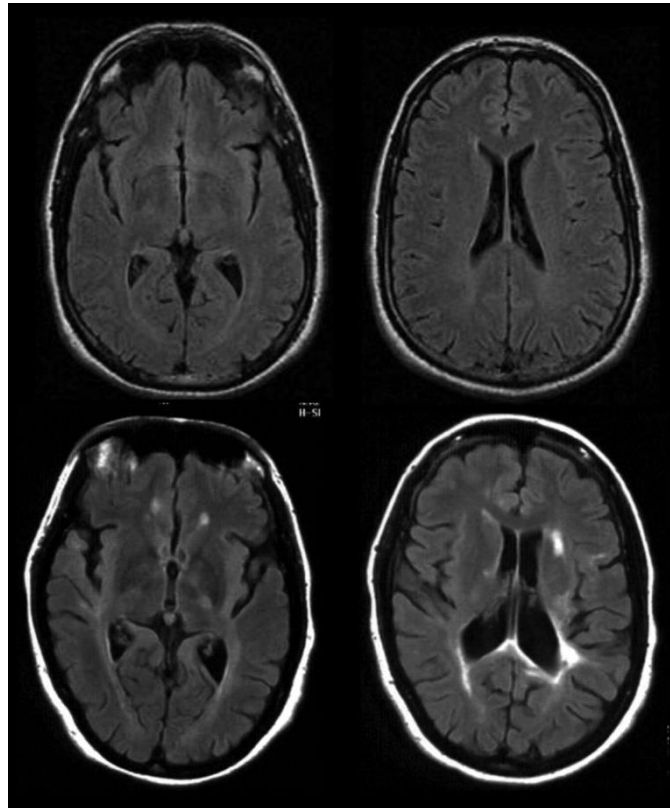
Brain MRI scans. Images are derived from a fluid-attenuated inversion recovery magnetic resonance, a kind of MRI scan. The images show MRI scans of the brain of a MS patient (bottom) and a healthy control (top). White matter MS lesion are shown as white spots against the healthy white matter which looks relatively dark. Images taken from Bakshi et al., 2004.
